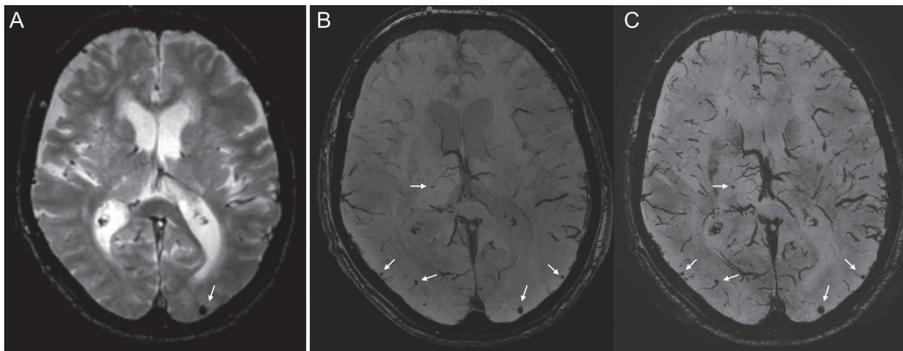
Increased visibility of cerebral microbleeds with increasing field strength: an example of a single slice T2*-weighted MR image at 3 Tesla MRI (A), and 7 Tesla MRI (first echo (B) and second echo (C)), showing four extra microbleeds at 7 Tesla MRI (arrows).
